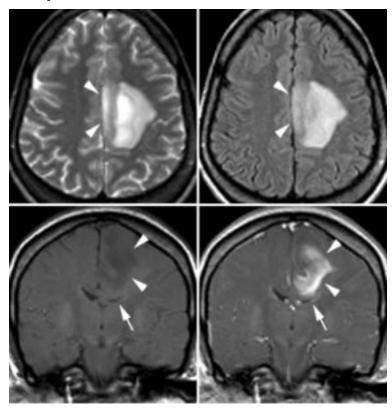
Axial T2-weighted (upper left) and FLAIR-weighted (upper right) brain MRI scans reveal a large hyperintense area in the left posterior frontal lobe, which also involves the ipsilateral corpus callosum (arrowheads in upper panels). Coronal T1-weighted images through the lesion (arrowheads) demonstrate a primarily subcortical hypointensity without gadolinium (lower left), which enhances peripherally after gadolinium administration (lower right). The lesion causes a mass effect with effacement of the underlying left lateral ventricle (arrows in lower panels) and rightward displacement of the falx cerebri (arrowheads in upper panels).
